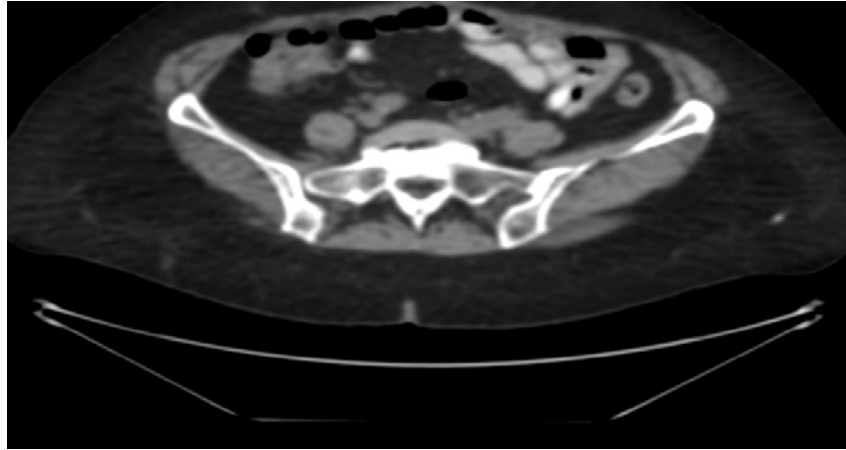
Fifty-year-old woman with small peritoneal seeding in pelvis and abdominal wall without positive findings in CT scan
